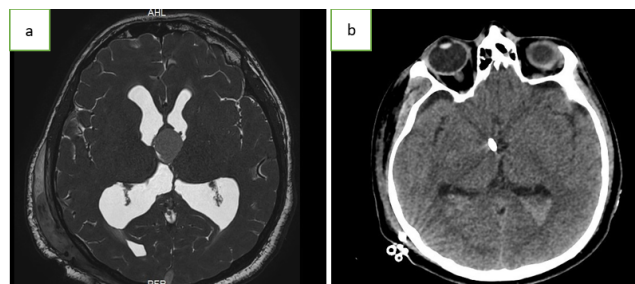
a: MRI brain showed a cystic lesion measuring 2.4x1.7x2.5 cm is seen at the level of 3rd ventricle with obstructive hydrocephalus; b: Right frontal craniotomy and excision of colloid cyst.
